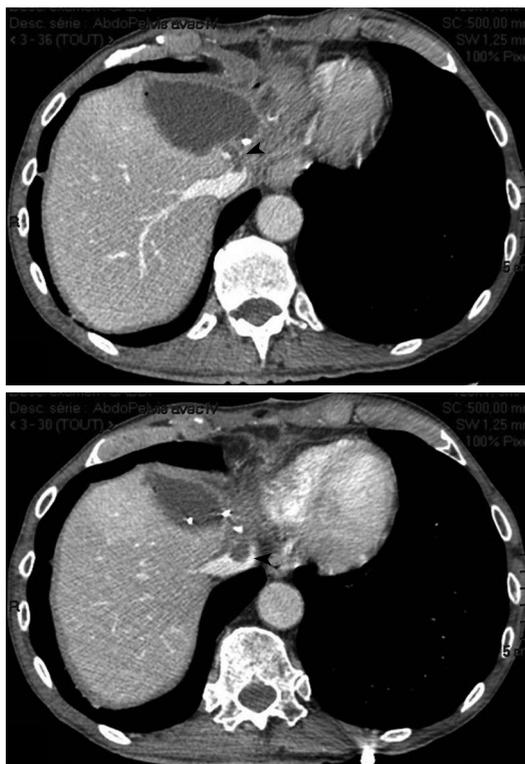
Postoperative computed tomography scan (day 17) in case 2. A biloma is present at the upper part of the transection plan and a defect is visible in the distal end of the middle hepatic vein extending in the inferior vena cava (arrowheads).
